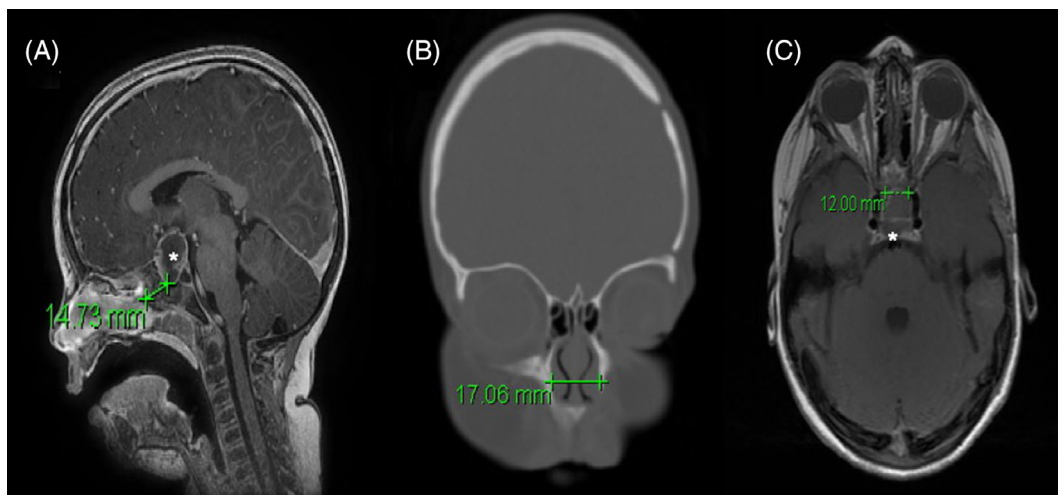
Preoperative planning in a 4 year old with craniopharyngioma. A, Extent of nonpneumatized sphenoid is measured on this sagittal T1 weighted magnetic resonance imaging (MRI) to estimate the extent of drilling required to access the sellar and suprasellar craniopharyngioma (asterisk). B, The piriform aperture is measured on this coronal computed tomography (CT) scan demonstrating an acceptably wide nasal access point. C, Intercarotid distance at the sella is measured on this axial T1 MRI revealing adequate intercarotid space for access to the craniopharyngioma (asterisk)
